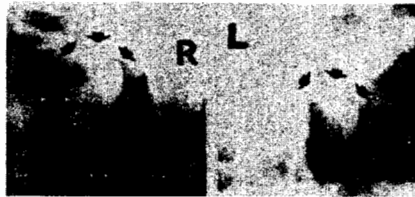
Preoperative radiographs of the right and left mandibular joints showing osseous ankylosis.
